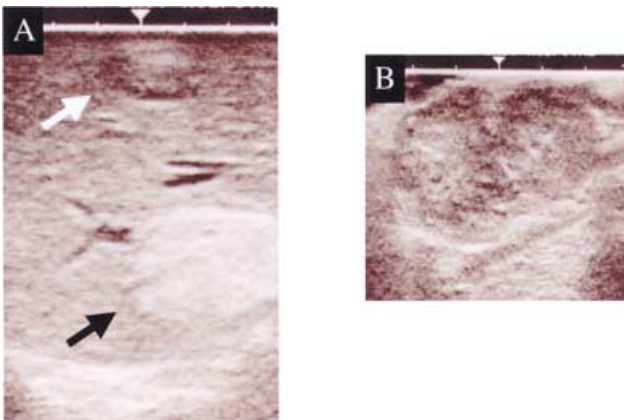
Ultrasonography : A A newly found tumor in the liver (Segment VIII) (white arrow) is a hypoechoic mass with a hyperechoic area, and different from the other mass existing in the liver (black arrow). B The omental tumor liver is a hypoechoic mass with a hyperechoic area.
